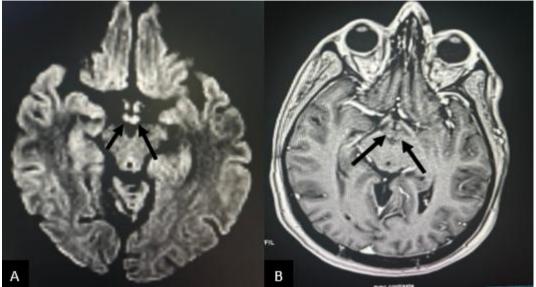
Diffusion sequence of a brain MRI in an 18-year-old patient showing hyperintensity of the mammillary bodies (A) and axial 3D T1 sequence after Gadolinium injection (B) showing moderate contrast enhancement at their level.
